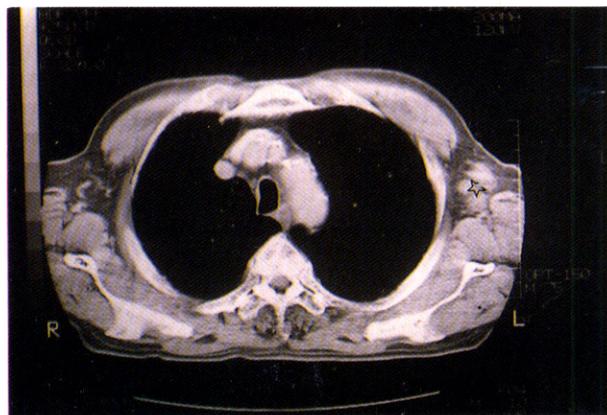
Left axillary (☆) and mediastinal lymph nodes (↑) were enlarged in chest CT.
